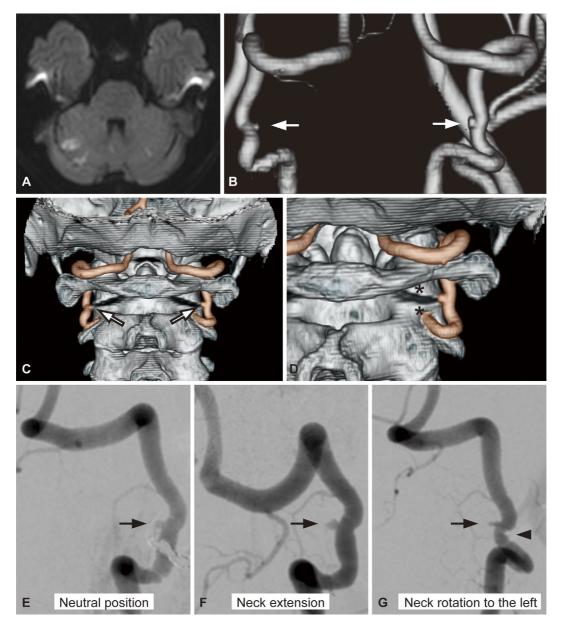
MRI, CT angiography and dynamic angiography. (A) Acute cerebellar infarction on initial MRI. (B) Bilateral vertebral artery aneurysms (arrows) on CT angiography. (C) Both aneurysms (arrows) are located at the atlantoaxial joint level. (D) Higher magnification of panel C, viewed from the right posterior side. Asterisks show facets of the atlantoaxial joints. (E-G) Angiography reveals a mild enlargement of the left aneurysm on neck extension (F) and an irregular endothelial surface near the aneurysm on neck rotation to the left (G, arrowhead), compared with the neutral position (E). Arrows indicate left vertebral artery aneurysm. (B-D: posterior views; E-G: anterior views.)
